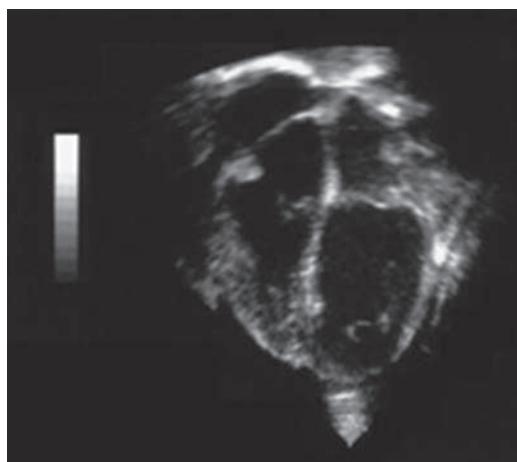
Ultrasound image of a beating heart
